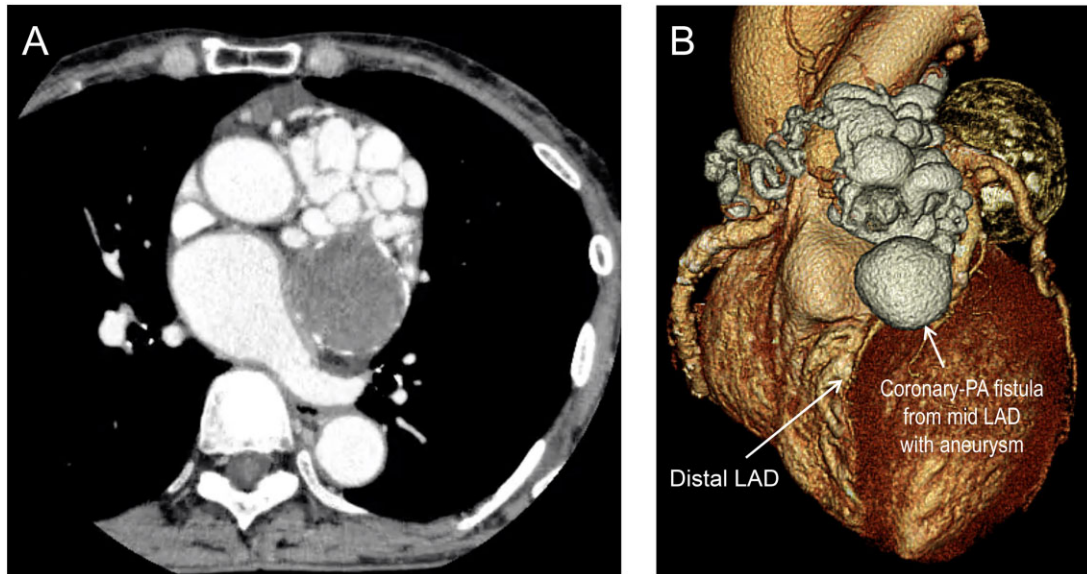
Contrast-enhanced cardiac computed tomography. (A) Contrast-enhanced cardiac computed tomography showed multiple contrast-enhanced nodules adjacent to the ascending aorta. (B) Three-dimensional reconstruction of coronary arteries using computed tomography angiography.
